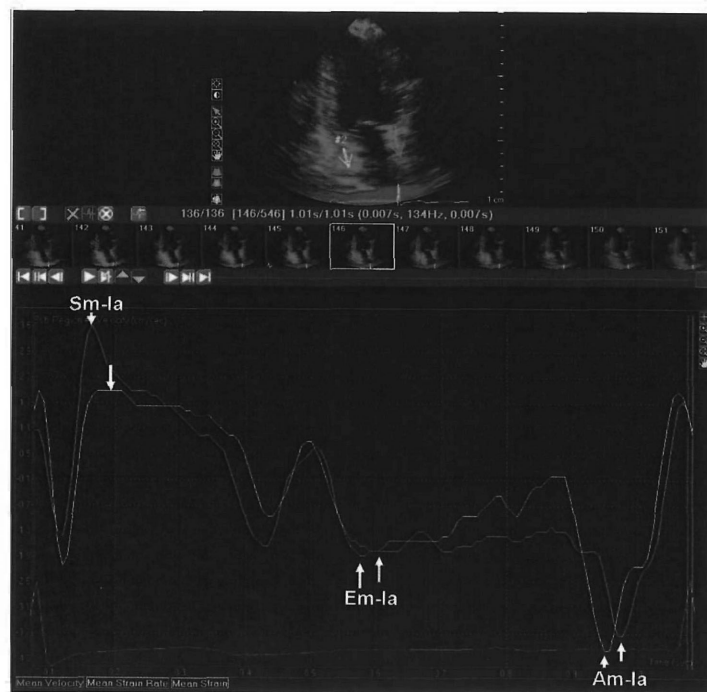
Example measurements of atrial velocities (Sm-Ia, Em-Ia and Am-Ia) in apical 4- (A) and 2-chamber (B) view during V-sense.
